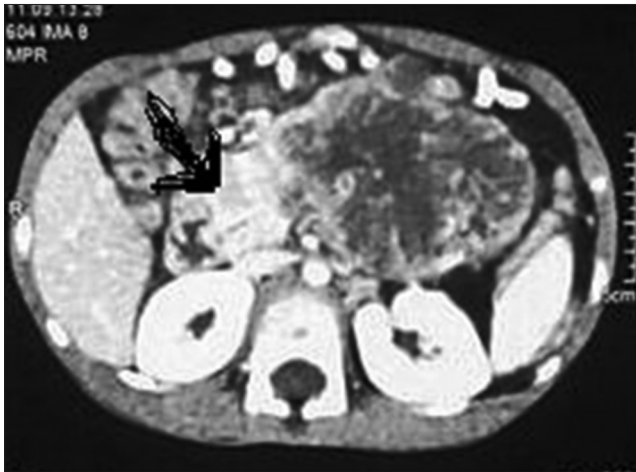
Contrast-enhanced computed tomography of abdomen showing neoplastic mass in pancreas (arrow)
